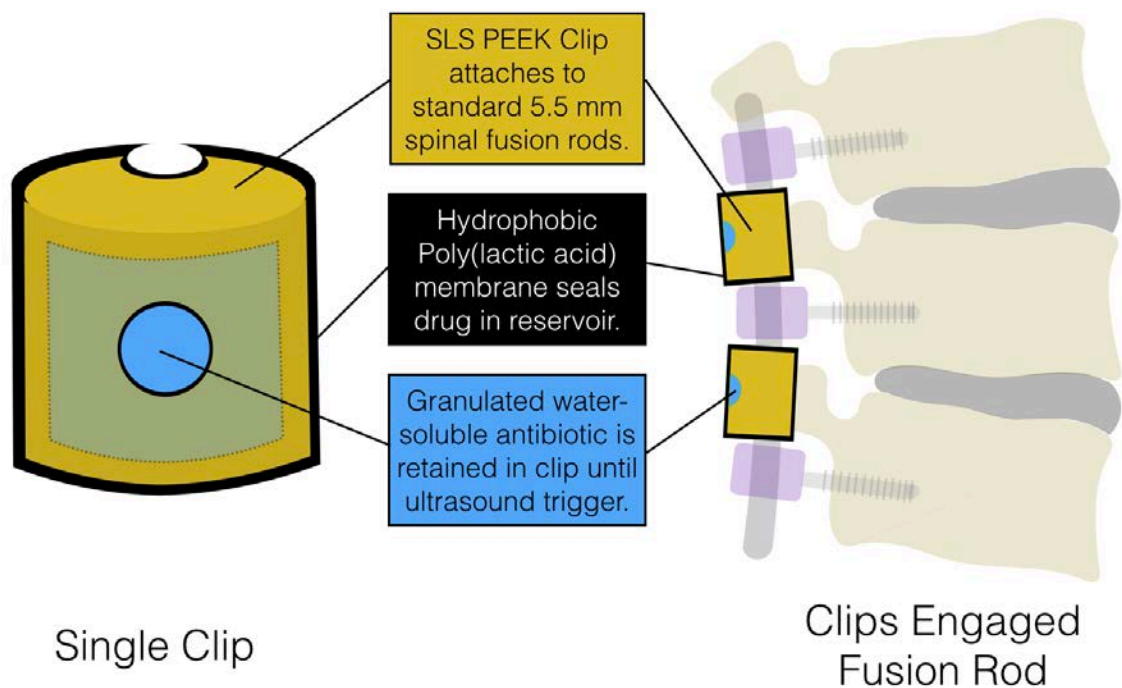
The SLS PEEK clip will attach to a spinal fusion rod at the time of surgery, initially containing a dose of antibiotic. The antibiotic is contained within a poly(lactic acid) membrane, which will rupture in response to an ultrasound trigger.
